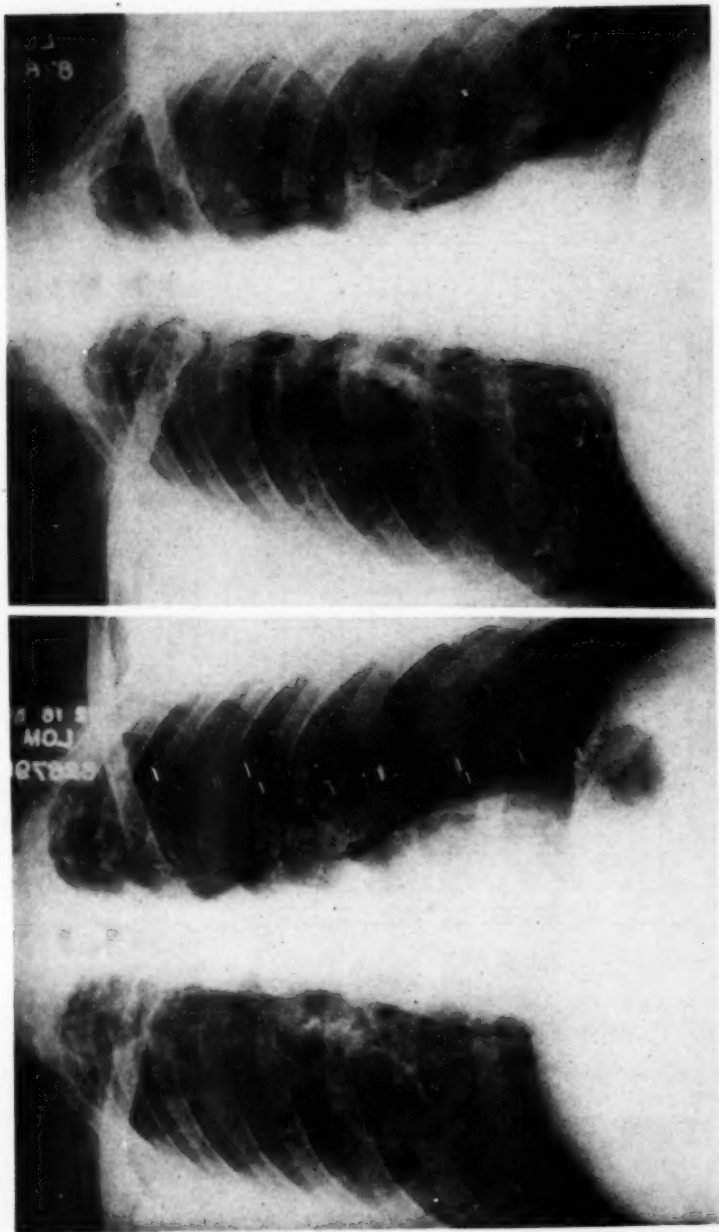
(left). Case 1. Chest roentgenogram at time cortisone was discontinued, after 17 days; 2,025 mg. were given. Infiltration has almost completely disappeared.
